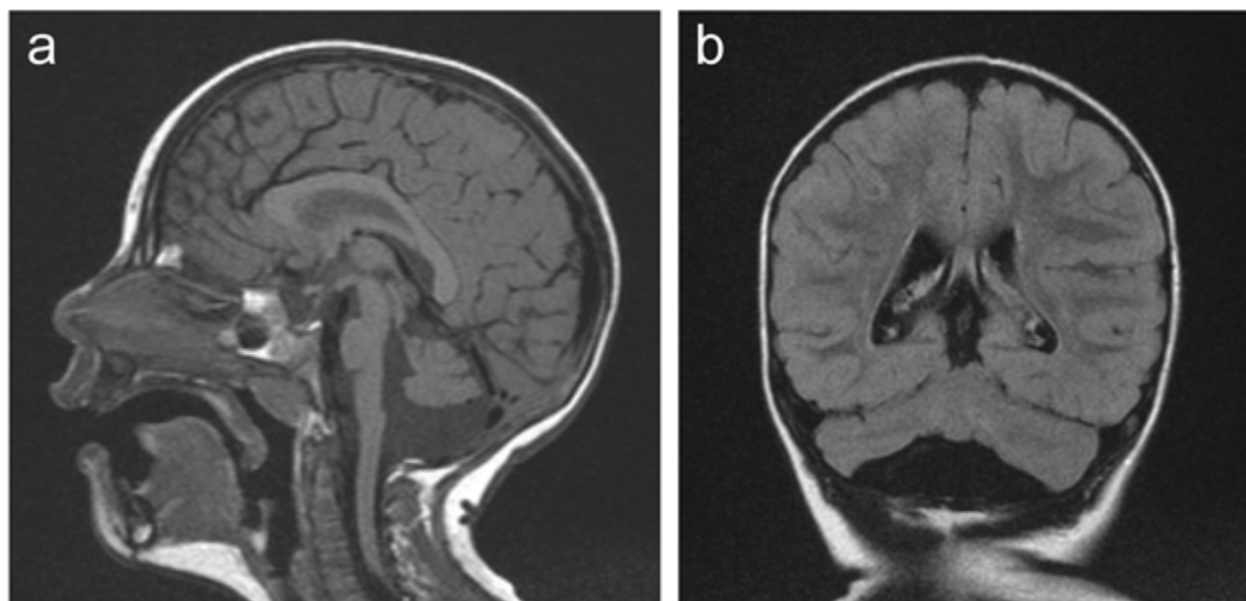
MRI of the brain of a girl age 2.5 years with MICPCH and a heterozygous *CASK* pathogenic variant
